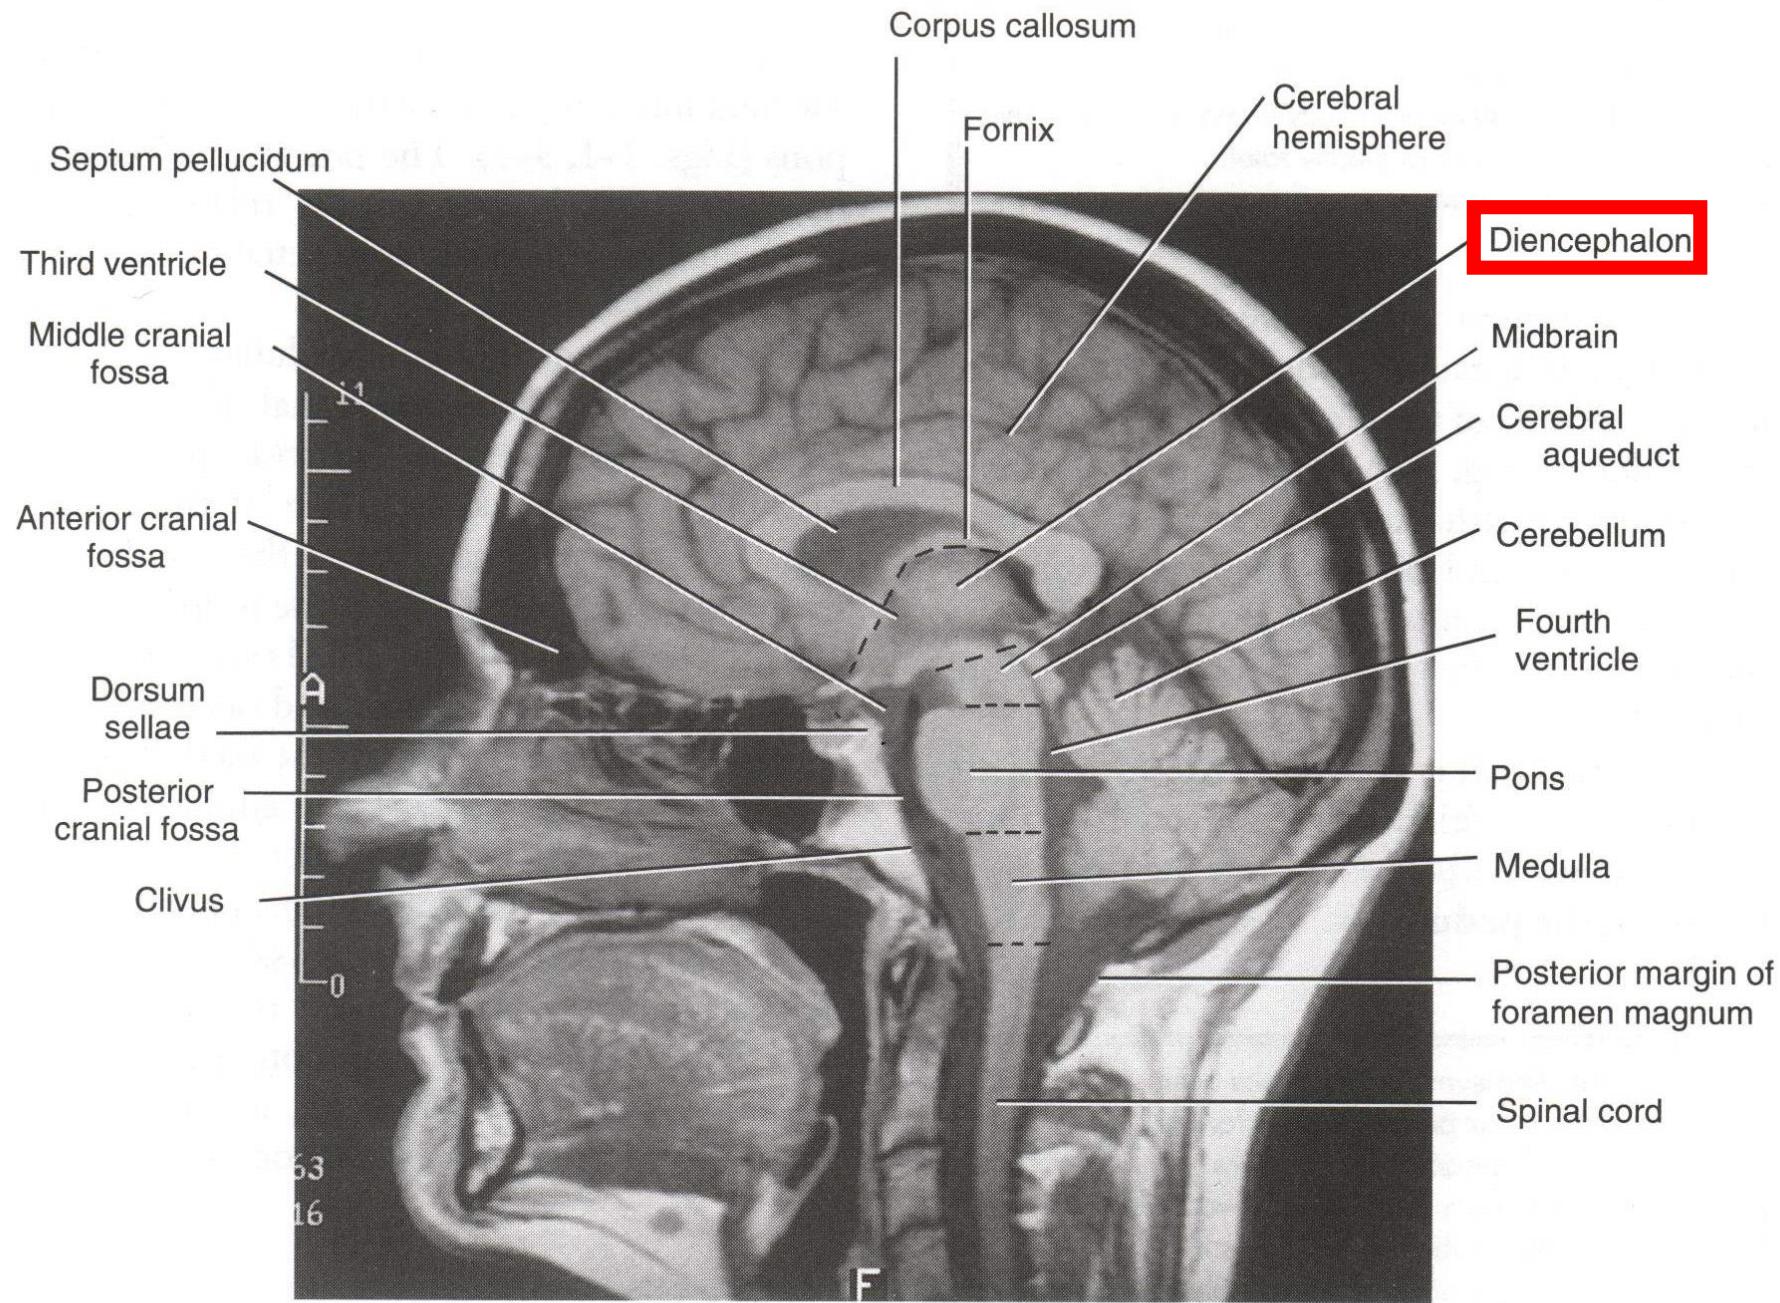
MRI median view of right half of brain.
